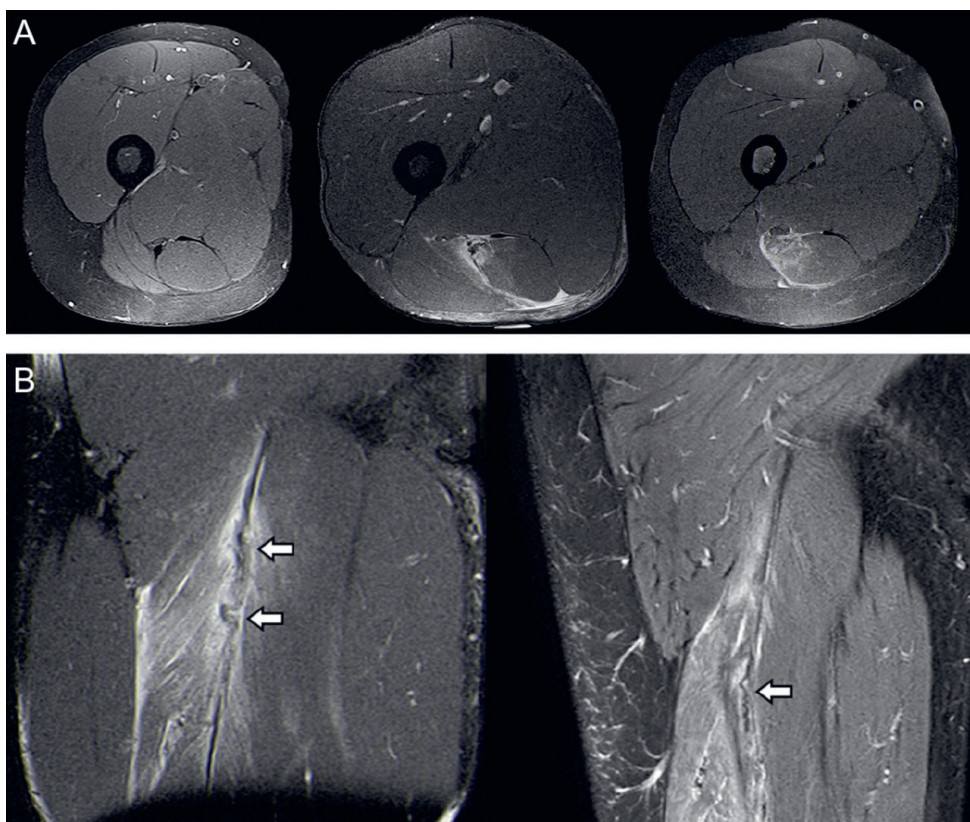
(A) Proton density with fat saturation (PD-FS) weighted axial MR images demonstrating no abnormality of the hamstring tendons (left), partial-thickness disruption of the intramuscular tendon with intrasubstance high signal intensity (middle) and full-thickness intramuscular tendon disruption (right). (B) PD-FS and T2-FS weighted coronal MR images demonstrating evident (left) and more subtle (right) waviness of the intramuscular tendon (arrows).
